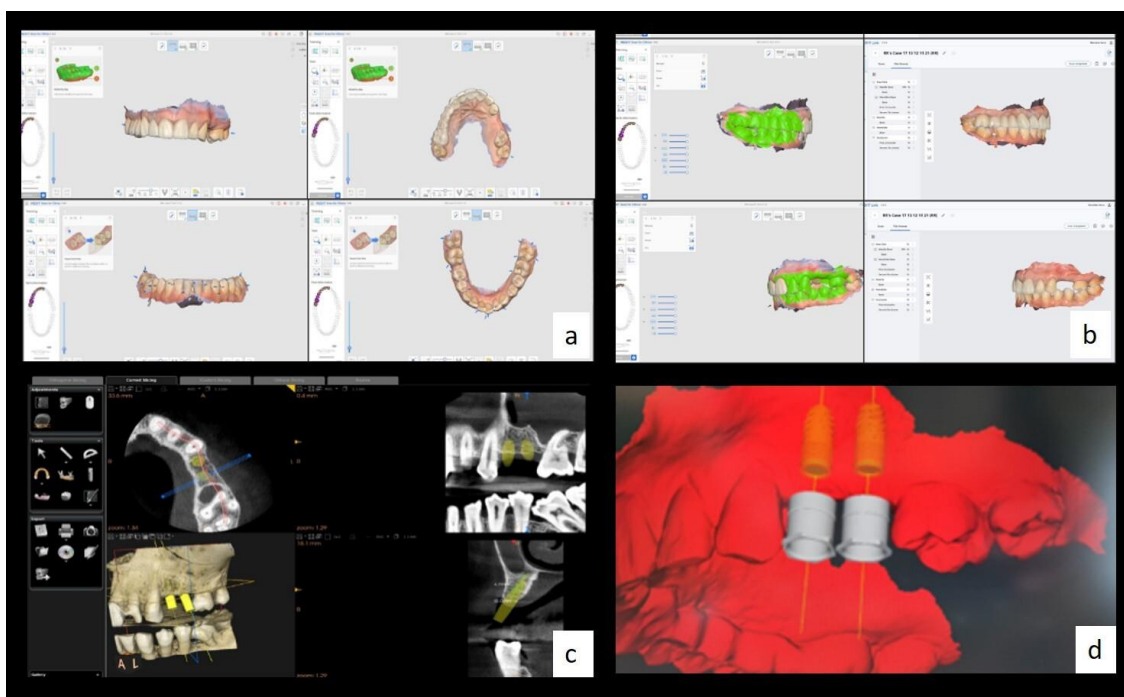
a) The intraoral scan viewed in the MEDIT Link software menu: the maxillary arch (anterior view, occlusal) and the mandibular arch (anterior view, occlusal). b) The intraoral scan with the intermaxillary relations recordings, in maximum intercuspation. c) CBCT aspect of the interest area (2.4 and 2.5 missing teeth) and digital planning of the implants position. d) Determining the final position of the implants and positioning the sleeves of the future surgical guide with ExoPlan software.
